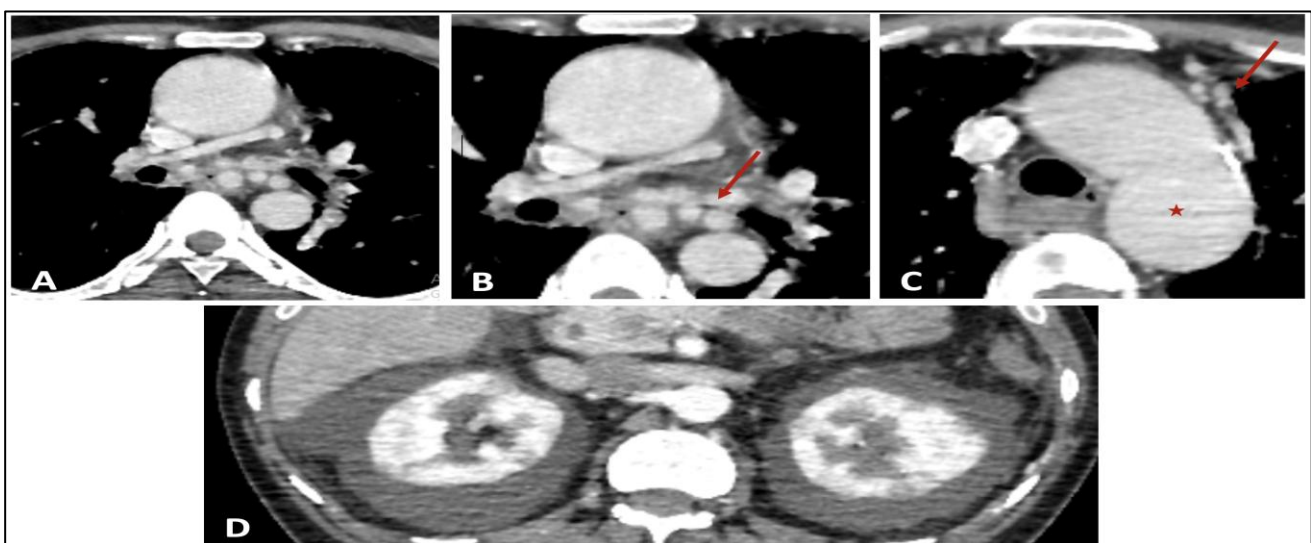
(A-D): Post-contrast CT axial images showing: A-severely stenotic main pulmonary artery and right pulmonary artery. B-multiple aorto-pulmonary collaterals around the carinal region (red arrow). C-aneurysmally dilated aortic arch (red star) and left prevascular region collaterals (red arrow). D-bilateral perinephric collection.
